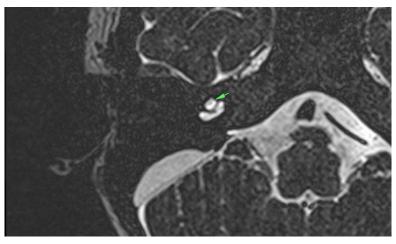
Axial section in MRI temporal bone showing ONE AND A HALF TURN COCHLEA (INCOMPLETE PARTITION 2) (arrow)
